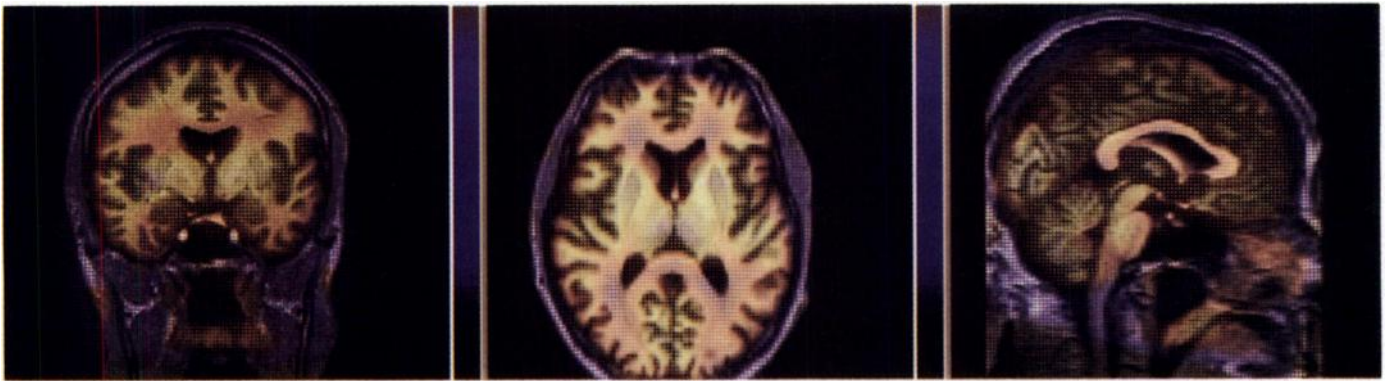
MR and SPECT images overlaid in coronal, transaxial and sagittal planes. Interactive alignment of MR and SPECT images was performed by manual step-by-step rotation and translation of the SPECT image sets. The interactive stepwise alignment was guided by visual inspection of images in different orientations to get the optimal overall agreement of neuroanatomy.
